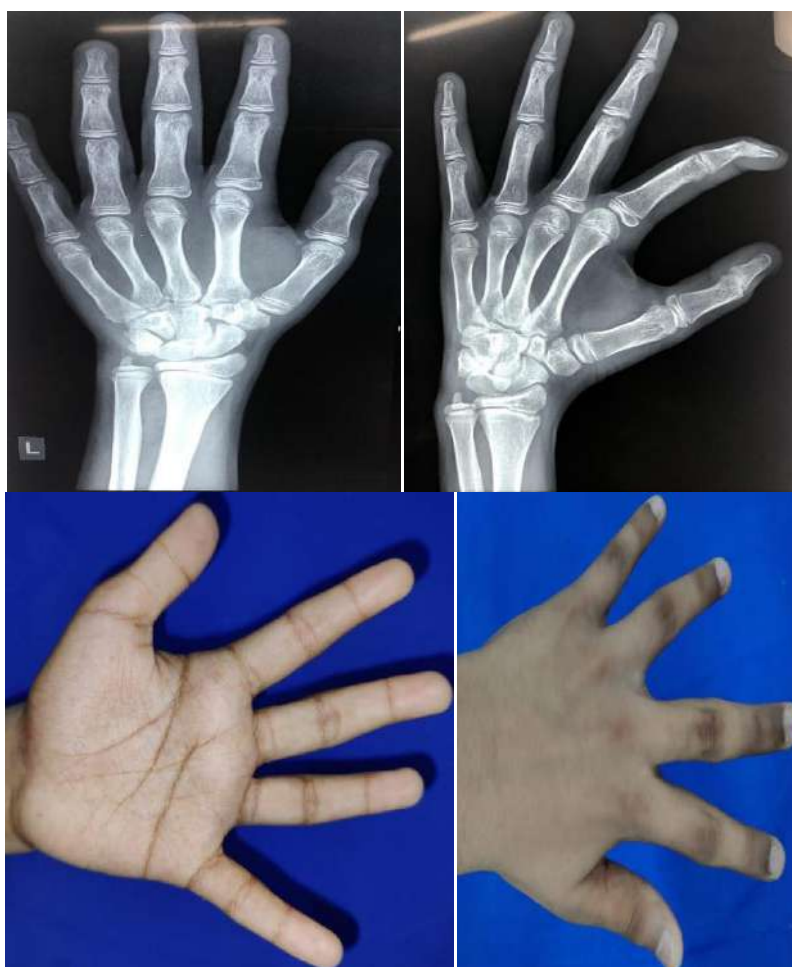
Post-op x-ray & postoperative follow up clinical pictures.
